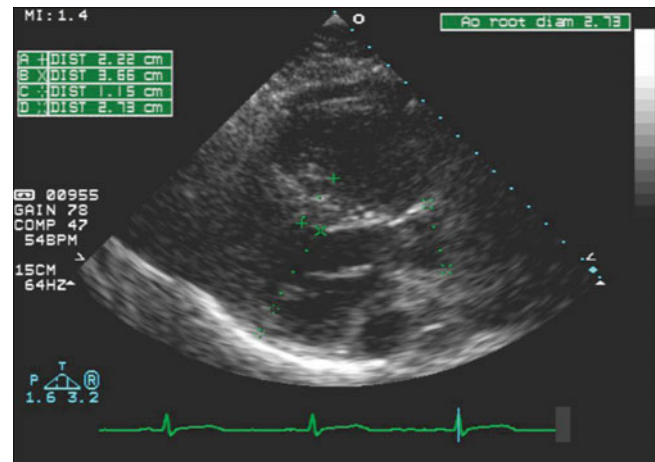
Case 3: TTE on initial evaluation depicting basal septal hypertrophy in parasternal long axis view
